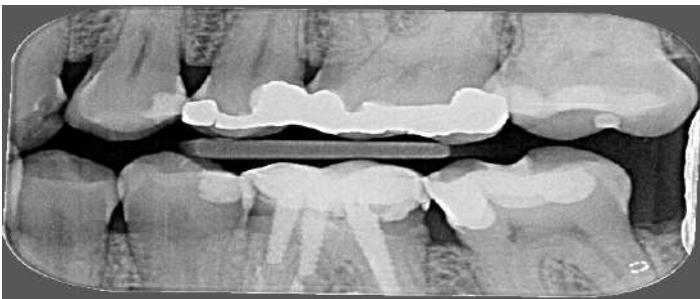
Bitewings on the left.
